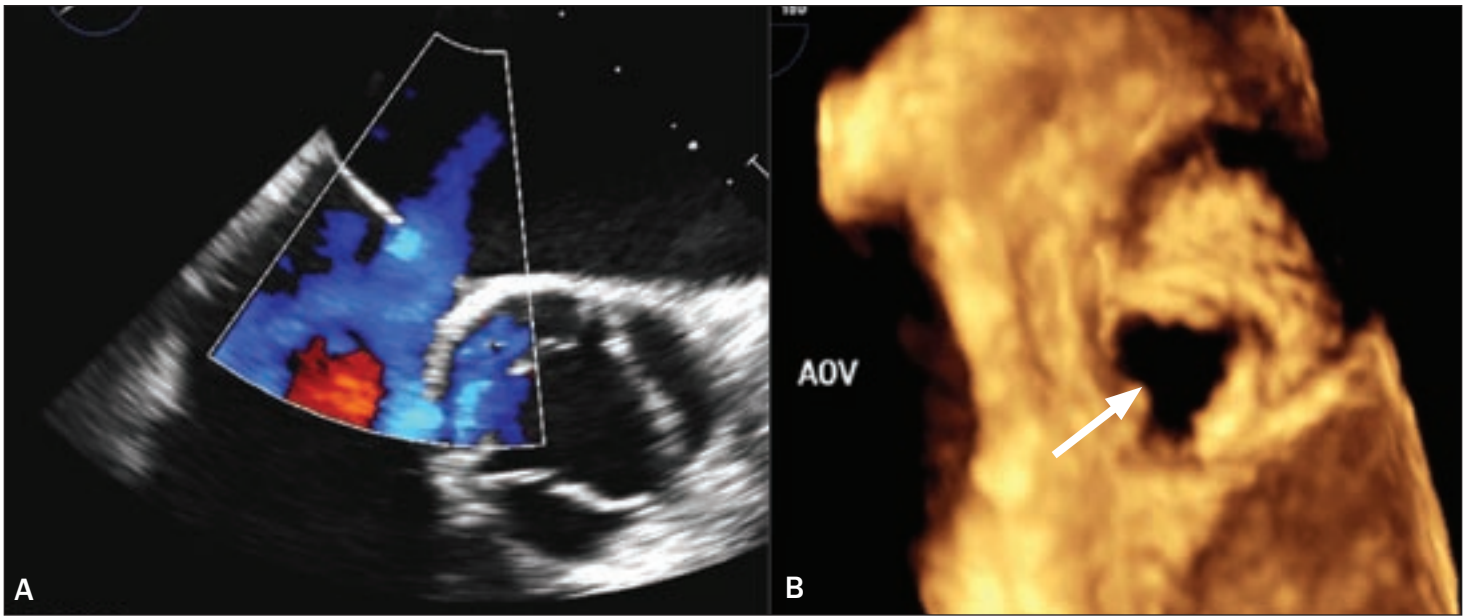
Ostium Secundum Atrial Septal Defect. A, 2D transesophageal echocardiographic image in a patient with an ostium secundum atrial septal defect; the defect is well seen with color Doppler indicating left to right flow. B, 3D echocardiographic en face image from the right atrial perspective gives a clearer picture of the true size, shape, and rim of the defect (arrow). This information can be useful in planning closure. AOV, aortic valve.
